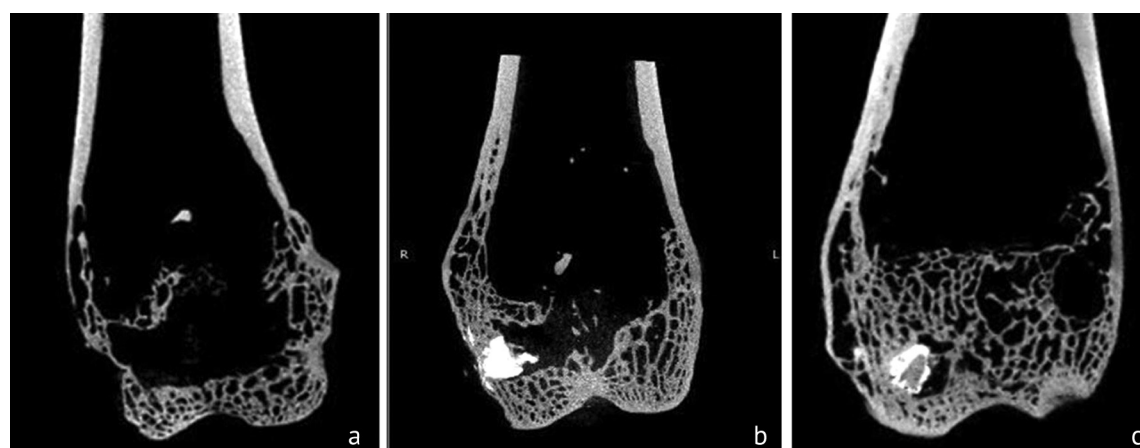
Variability in the structure of the distal epiphysis of the femur, CT reconstruction with a slice thickness of 1 mm
